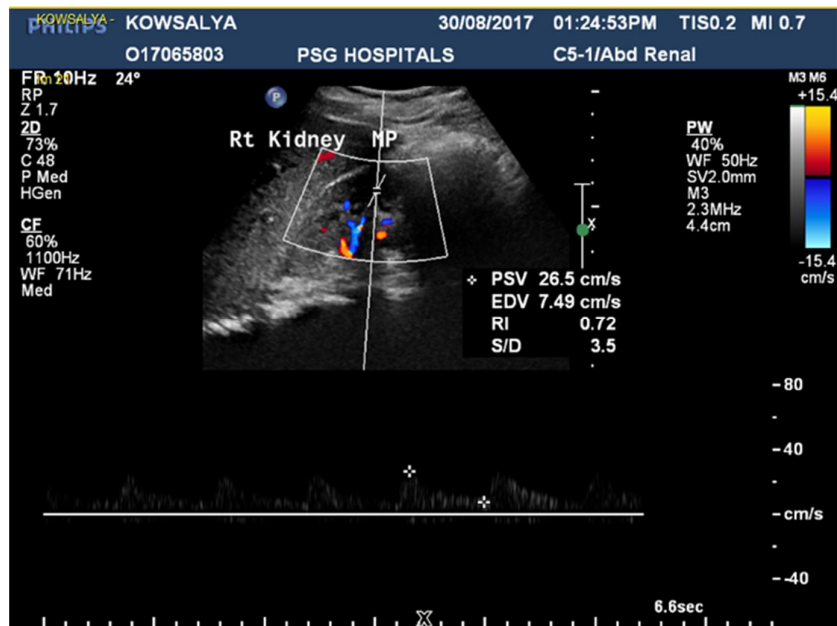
(B) Doppler US demonstrating an RI value of 0.72 in the mid pole right kidney (obstructed).
